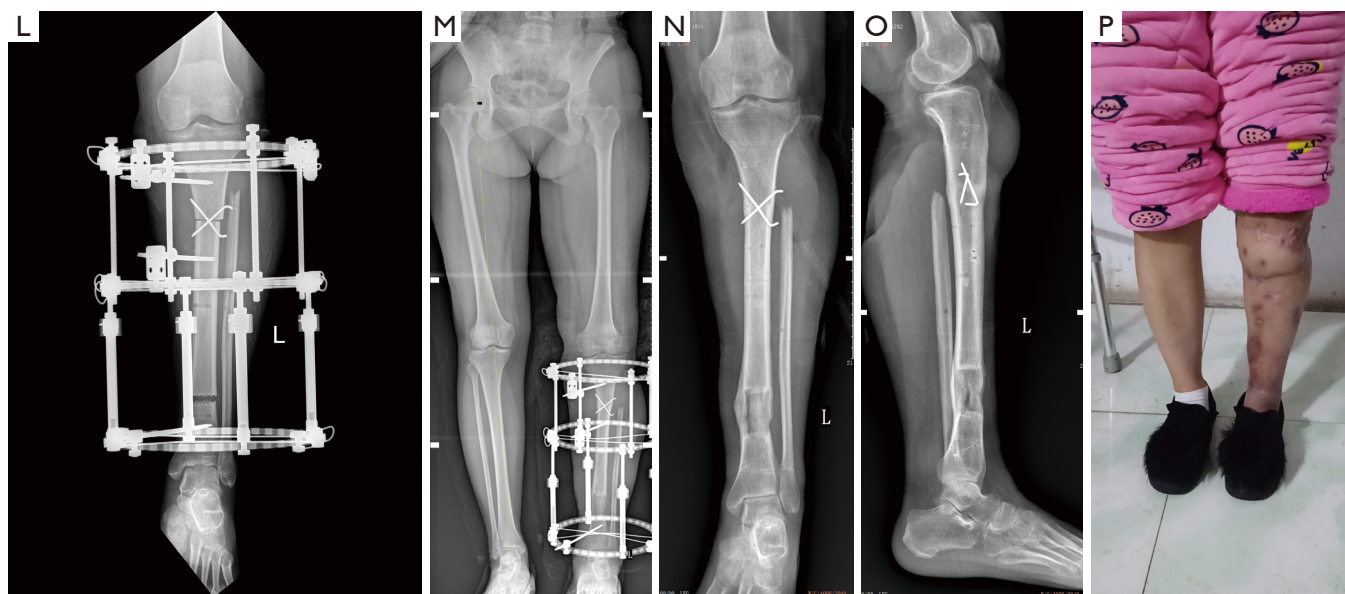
A typical case. (A,B) Appearance and radiograph of the knee injury before emergency operation; (C) repair of posterior tibial artery and vein during operation; (D,E) the appearance and radiograph of the injured knee after emergency operation; (F,G) appearance of the wound in the recipient site and flap design in the donor site; (H) anastomosis of descending genicular vessel in the recipient area; (I,J) appearance of the injured knee after repair with the skin flap and skin graft; (K,L) photograph showing left limb lengthening during surgery and radiograph of the left limb a week after surgery; (M,N) full-length standing anteroposterior radiograph of the lower extremity; (O,P) appearance and radiograph of the lower limb 2 months after removing the external fixation device.
